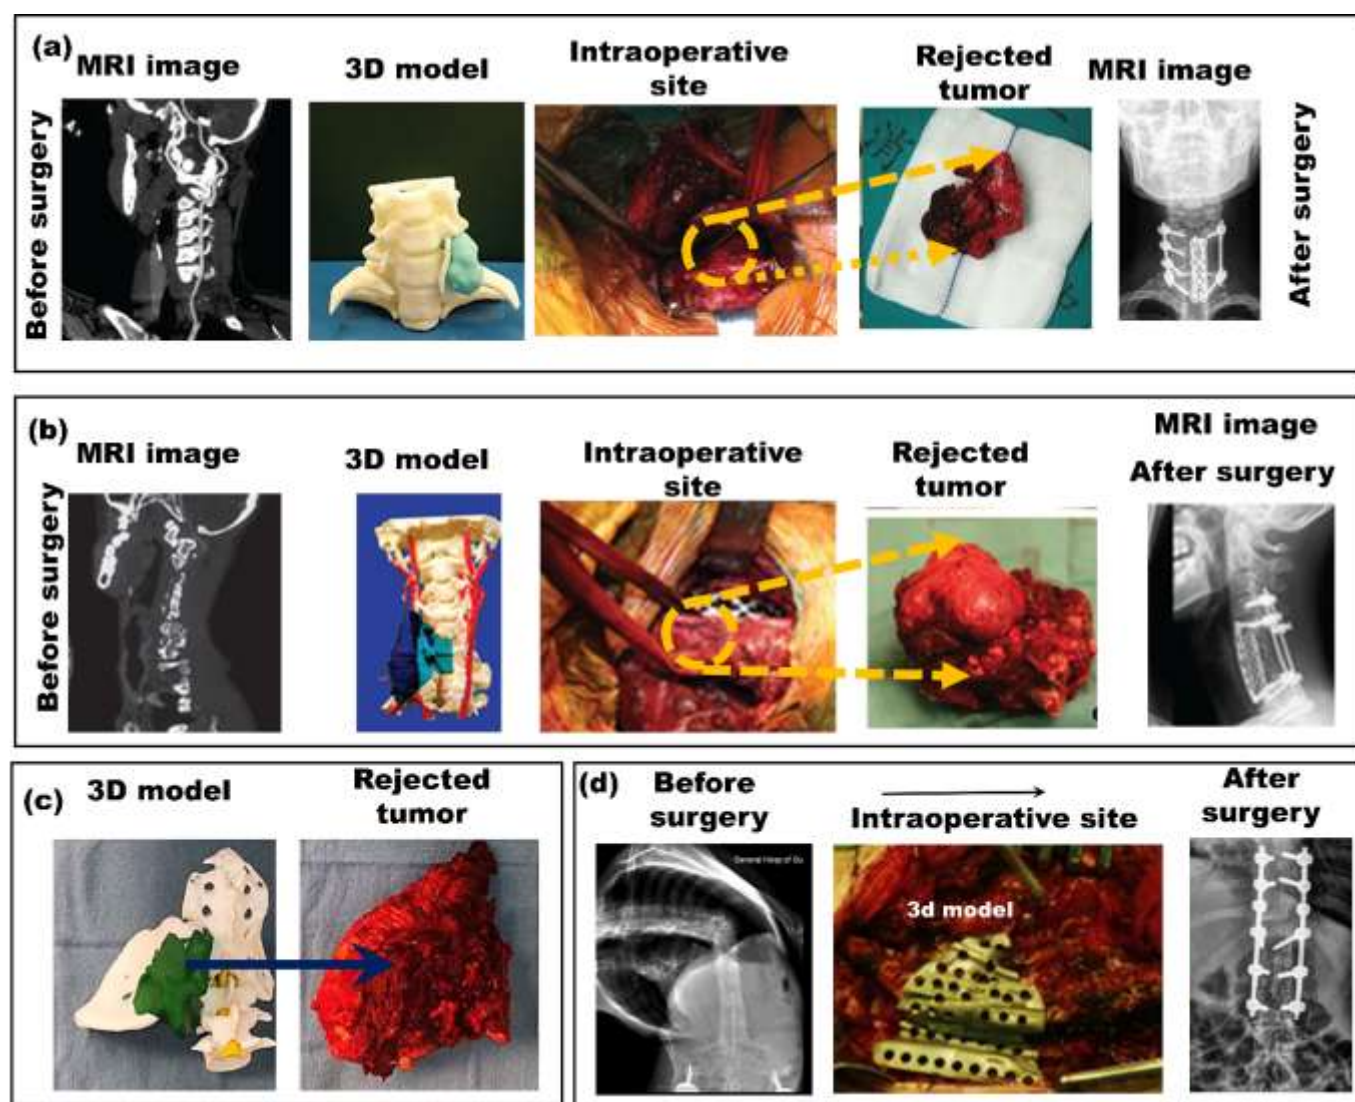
(a) En-bloc removal of the tumor, Figure reproduced from Xiao et al.^[194] (b) removal of a tumor in the right vertebral artery; Figure reproduced from Yang et al.^[197] with permission from John Wiley and Sons, copyright (2016) (c) A 3D-printed model of the extracted tumor; Figure reproduced from Li et al.^[200] (d) surgical correction of severe kyphoscoliosis by customized guiding templates. The process from the CT scan before surgery on the upper left to the post-operative CT scan on the right; Figure reproduced from Tu et al.^[202] with permission from Elsevier, copyright (2019)
